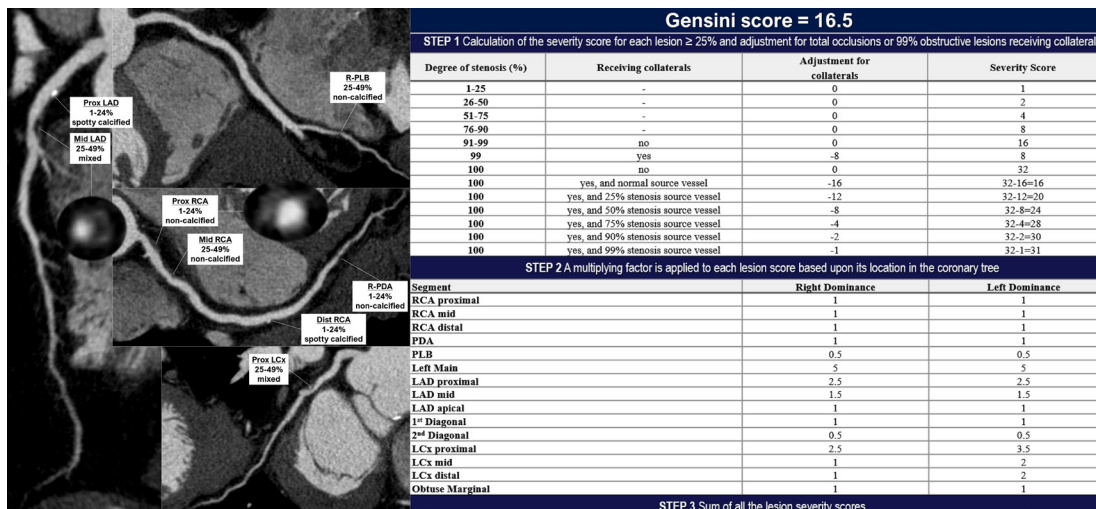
CT-adapted Gensini score calculation. An example of Gensini score calculation from CCTA dataset (curved multiplanar reconstruction) in a MINOCA patient. CCTA, cardiac CT angiography; MINOCA, myocardial infarction with non-obstructive coronary arteries; R-PDA, right posterior descending artery; RCA, right coronary artery; LCA, left coronary artery; LAD, left anterior descending; LCx, left circumflex; R-PLB, right posterolateral branch.
